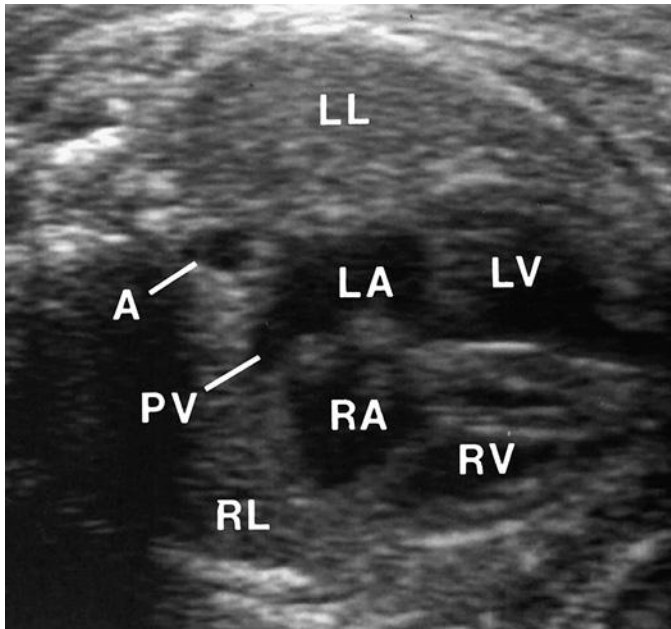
Transverse axial sonogram of the fetal thorax. A, descending aorta; LA, left atrium; LL, left lung; LV, left ventricle; PV, pulmonary vein; RA, right atrium; RL, right lung; RV, right ventricle.
